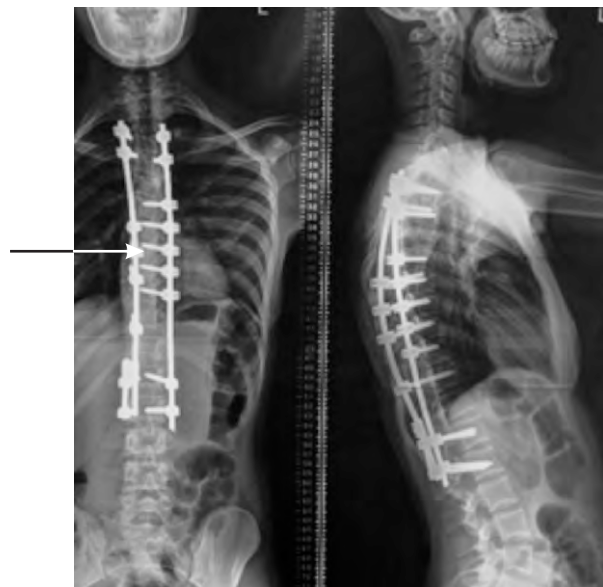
Postoperative X-rays showing significant correction of scoliosis with metal rods (arrow).
